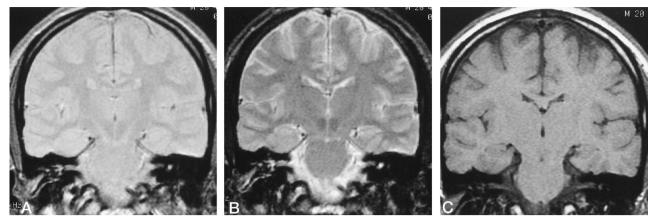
Right mesial temporal sclerosis with unremarkable MR findings. Coronal proton density–weighted (2800/30/1) (*A*), T2-weighted (2800/80/1) (*B*), and T1-weighted (450/16/2) (*C*) images show no evidence of signal or volume abnormality in the right hippocampus. The patient was seizure free at 12-month postsurgical follow-up.
